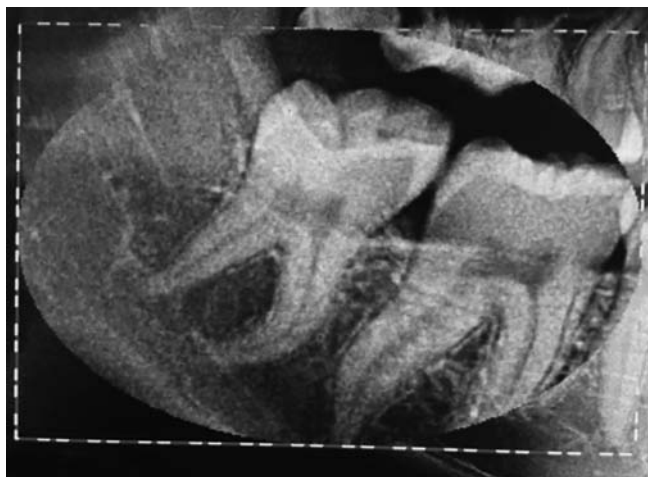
Preoperative orthopantomogram
